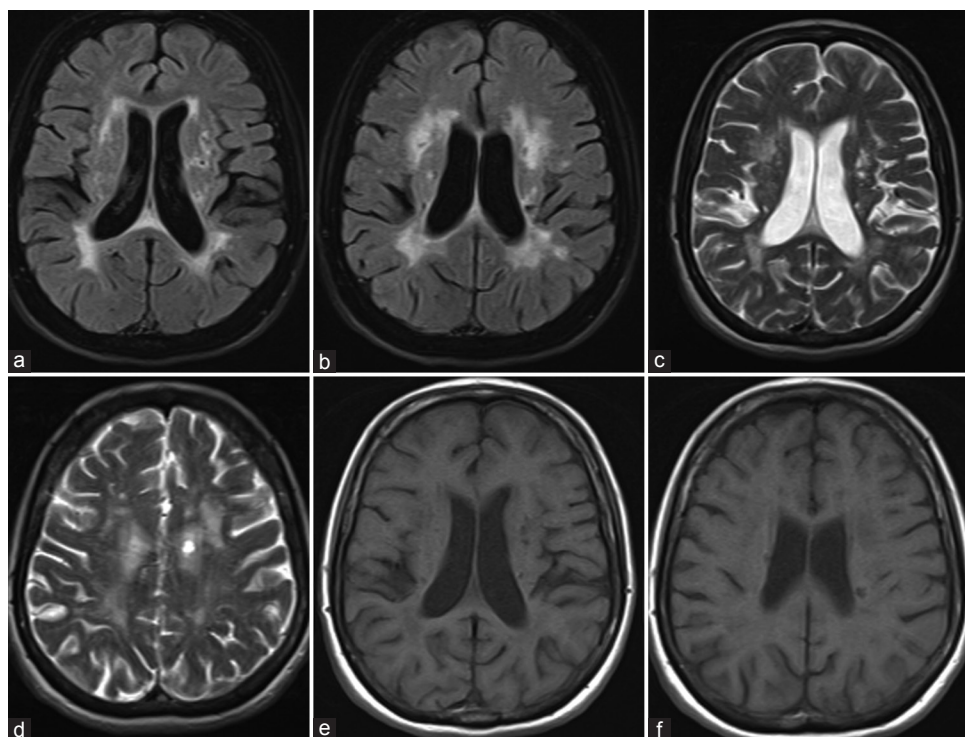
Cranial MRI FLAIR (a,b), T2 (c,d), and T1 (e,f) axial sequences of Case 1. MRI: Magnetic resonance imaging, FLAIR: Fluid-attenuated inversion recovery
